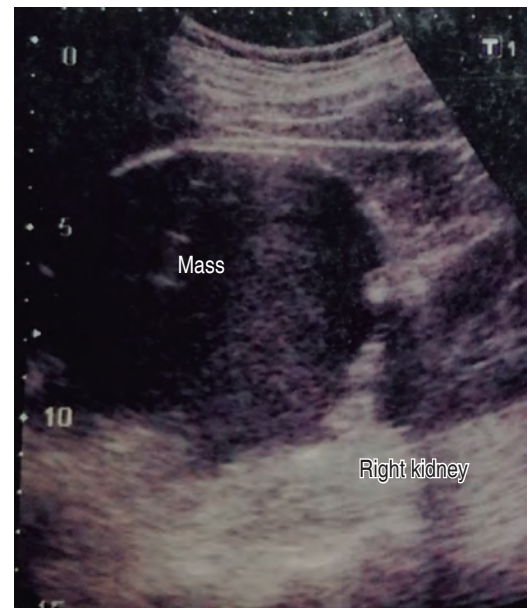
Ultrasound with image of a simple cyst located in the right lower hepatic border.
